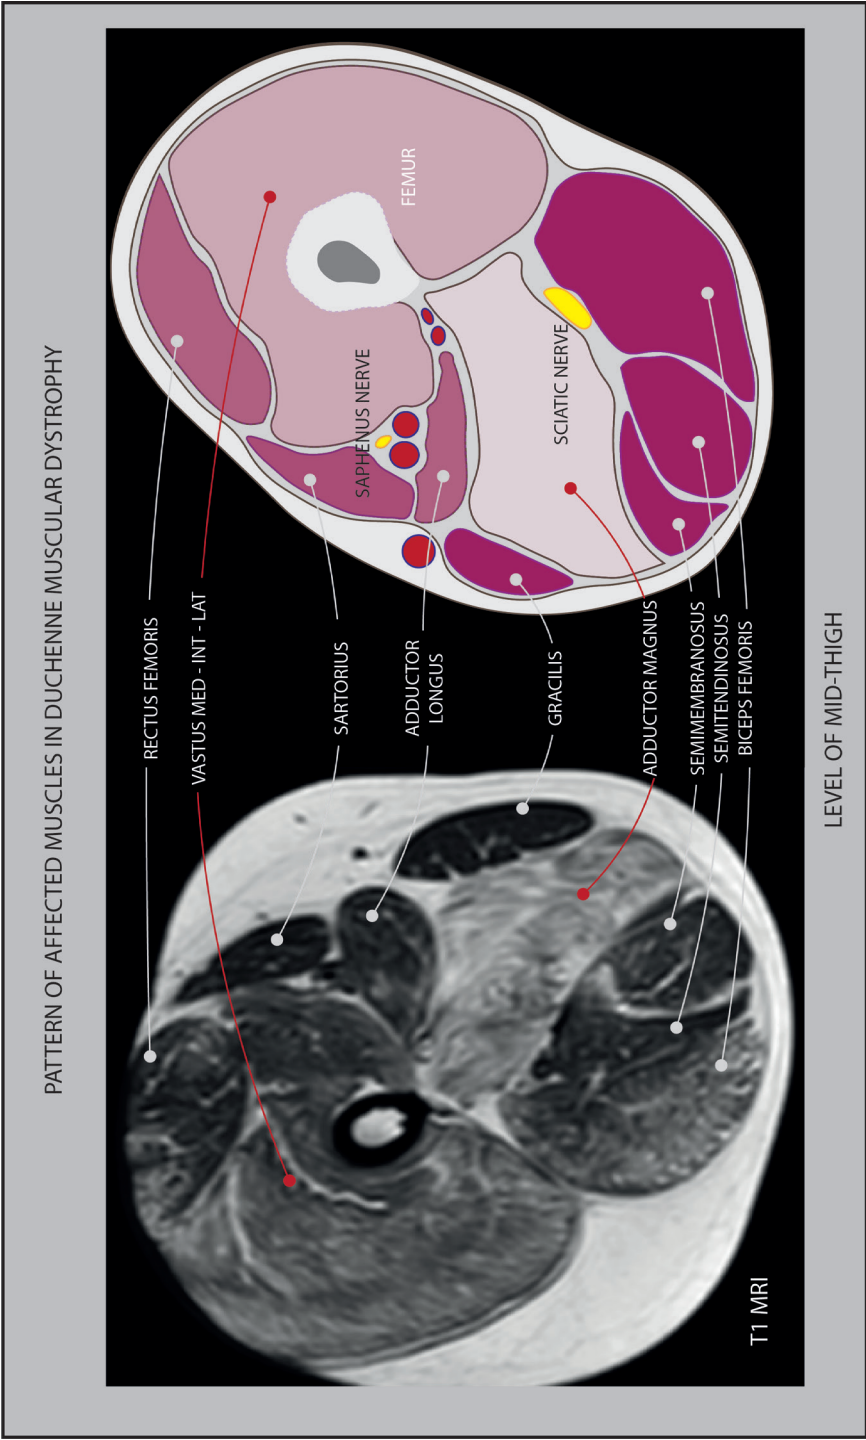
Pattern of affected muscles in Duchenne muscular dystrophy. The adductor magnus and vastus medialis, vastus intermedius and vastus lateralis are primarily involved in this disease. Left: MRI T1 Imaging at the level of the mid-thigh in a patient with Duchenne muscular dystrophy²⁴. Right: annotated outlines of the (involved) muscles.
